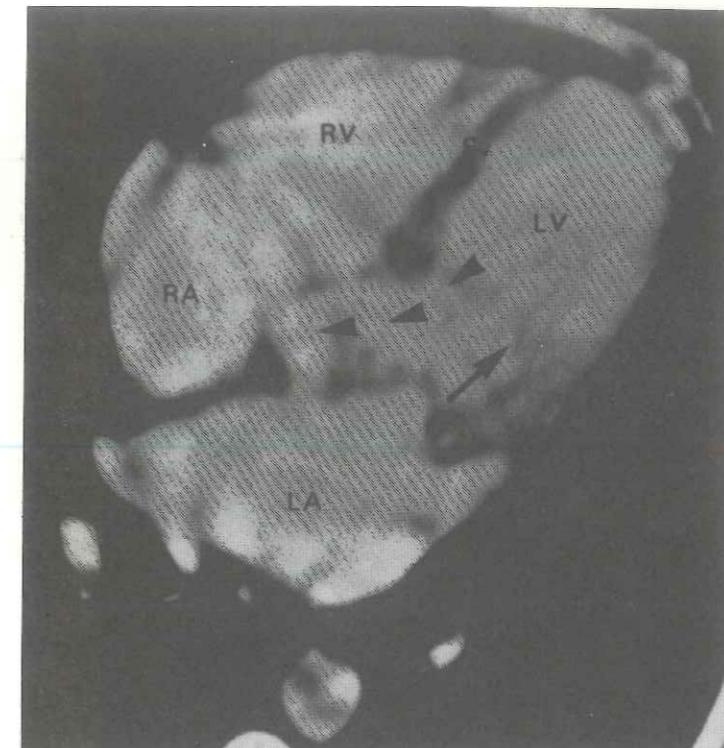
Ungated cardio-CT. Slice plane in the outflow tract of the left ventricle. RA = right atrium, RV = right ventricle, Sv = ventricular septum, LV = left ventricle, LA = left atrium, → = inflow tract, ▲ = outflow tract.
